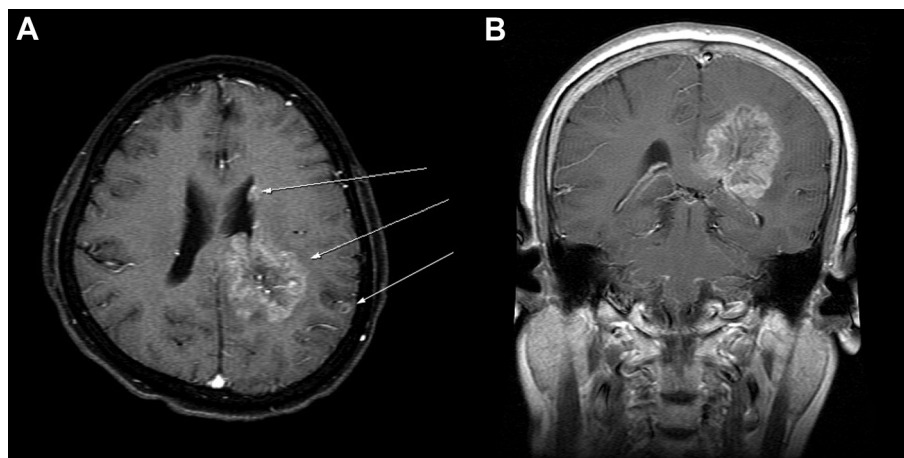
Magnetic resonance imaging of the patient's brain. (A) Axial T1-weighted image with gadolinium enhancement shows a large left-sided parieto-occipital lesion, located at the subcortical region but extending into the ipsilateral corpus callosum, and two concurrent small lesions in the ipsilateral lateral ventricle wall and parietal cortex (arrows). (B) Coronal section of the largest lesion shows compression of the left lateral ventricle and extension into the corpus callosum.
